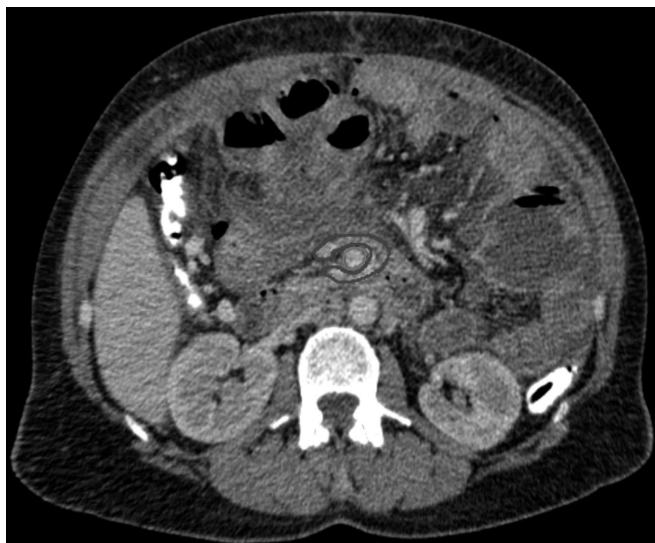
Transverse section CT of the abdomen. The red mark shows the superior mesenteric artery, and the blue mark shows the superior mesenteric vein.
